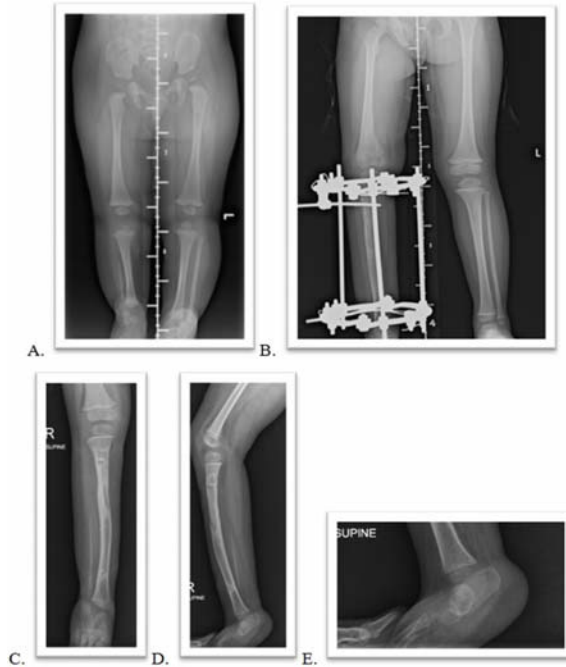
Fibular hemimelia type Ib is shown above A) Preoperative standing radiograph of six-month old girl presenting with right fibular hemimelia type Ib with a limb-length discrepancy of 7 cm at initial and absent a toe B) Radiograph of lengthening using the Ilizarov method showing equal limb length with good bone consolidation C-E) Postoperative radiograph of 33-month-old girl after bone lengthening, showing mild equinus foot.
